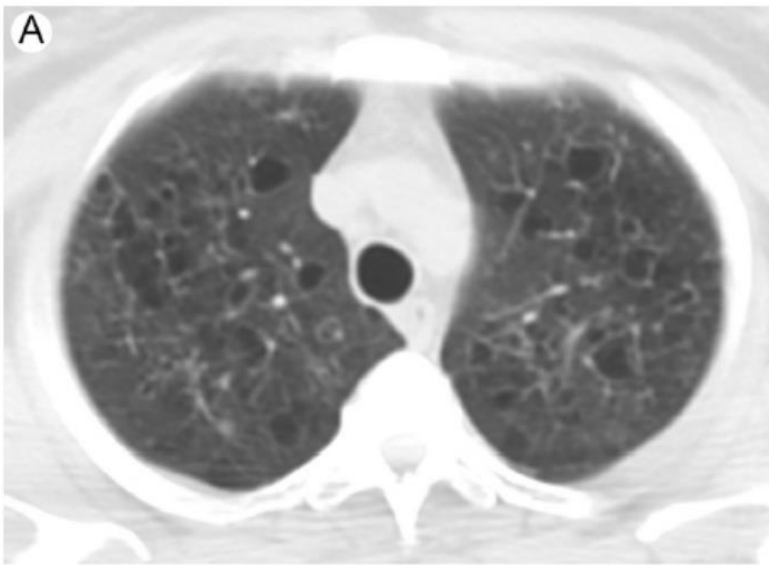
Lymphangioleiomyomatosis. Axial CT images at level of carina (A) and top of right diaphragm (B) in a 46-year-old woman reveal multiple well-circumscribed cysts distributed evenly throughout the lung parenchyma.
